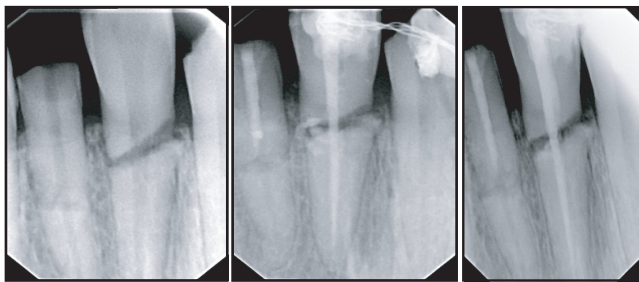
Initial radiograph. Figure 2 : Just after treatment Figure 3 : After 3 weeks
